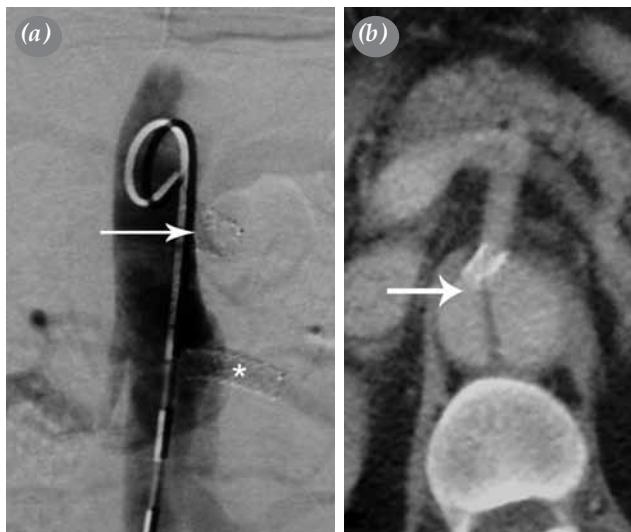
(a) Digital subtraction angiography and (b) computed tomography image of a 57-year-old male patient with type B aortic dissection treated with three endovascular stent grafts. The celiac trunk (arrow) and left renal artery (asterisk) were stented. Also, note the extension of the stent through the true lumen into the celiac trunk.
